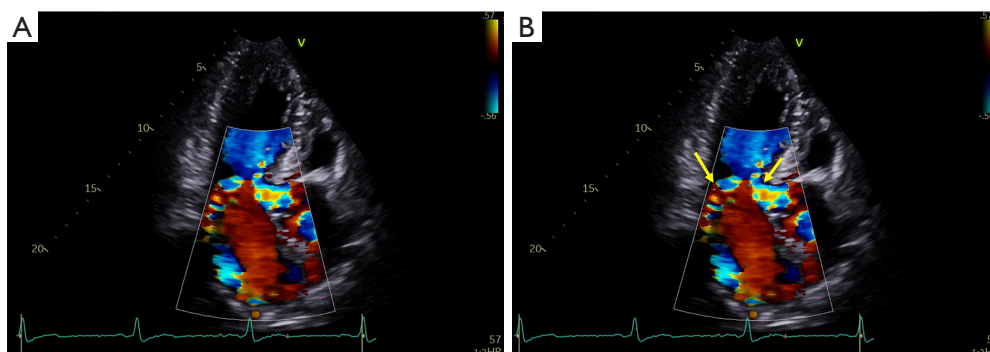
Color Doppler assessment at late systole of left ventricular outflow tract obstruction and mitral regurgitation in obstructive hypertrophic cardiomyopathy. (A) An apical 3-chamber view with color Doppler assessment; (B) the left arrow points to eccentric posteriorly-directed mitral regurgitation secondary to systolic anterior motion of the mitral valve; note the ‘Coanda’ effect of the regurgitant jet. The right arrow points to flow acceleration and turbulence in the left ventricular outflow tract as systolic obstruction occurs.
